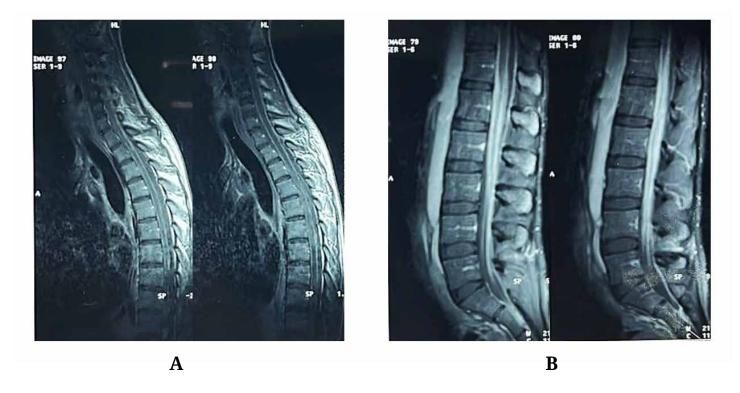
Sagittal spinal MRI on T1-weighted with Gadolinium enhancement of the first case report. A: Cervical and dorsal spine. B: Lumbar spine.
